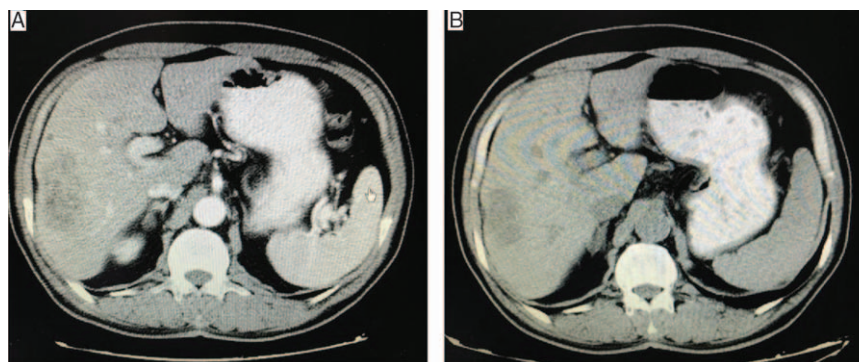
The abdomen CT scan revealed low density liver metastases with irregular margins. A, Focal uneven liver metastases (8.8 × 4.5 cm) before chemotherapy. B, Liver metastases (5.2 × 3.7 cm), after 12 cycles of FOLFOX6 chemotherapy: (oxaliplatin 175 mg d1 + fluorouracil 800 mg d1, fluorouracil 4000 mg (civ), and calcium folinate 800 mg d1).
